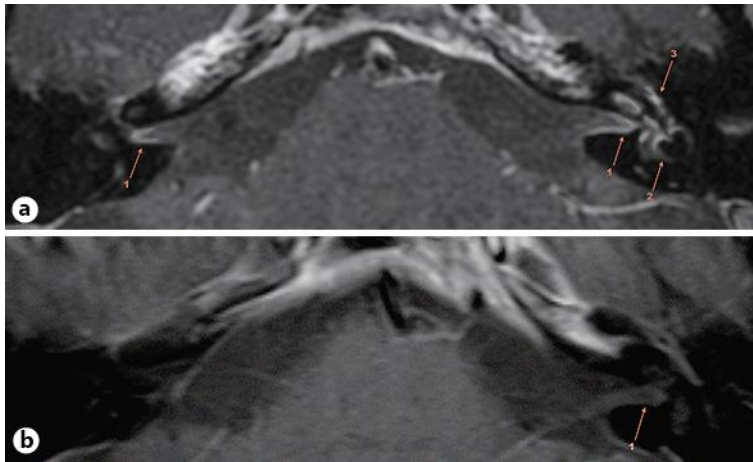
MRI studies of the skull base focusing on the pontocerebellar angles in the acute stage (a) and 9 months later following successful treatment and functional recovery (b). a In the acute stage, gadolinium contrast agent enhancement of the 8th cranial nerves on both sides (1), both inner ears with predominance on the left (2) and the facial nerve on the left (3) were found. These findings were interpreted as a result of a spread of the inflammatory process via the endolymphatic and/or the perilymphatic fluids. b In April 2012, the MRI only showed a slight residual enhancement of the 8th cranial nerve on the left side (1), while the MR morphology of the other structures had returned to normal.
